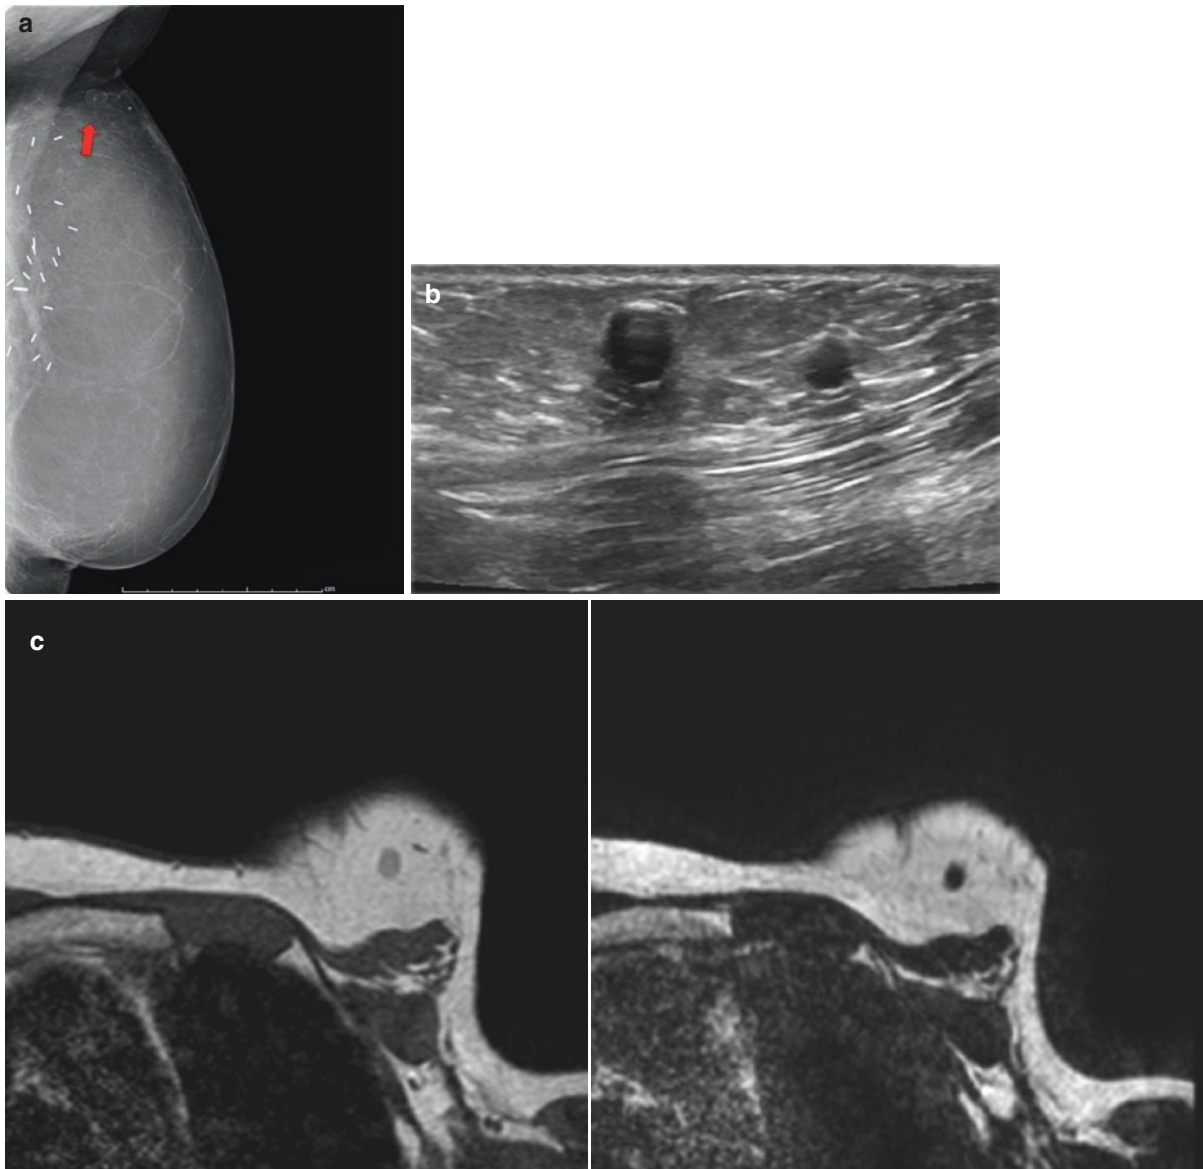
Patient with left mastectomy and autologous reconstruction with a DIEP flap and lipofilling injection a second time in upper quadrants to fill a small defect. The patient presented with a new palpable lump at some time after injection. Mammogram, ultrasound, and MRI were performed, and a BI-RADS® 2 classification was made. (a)
